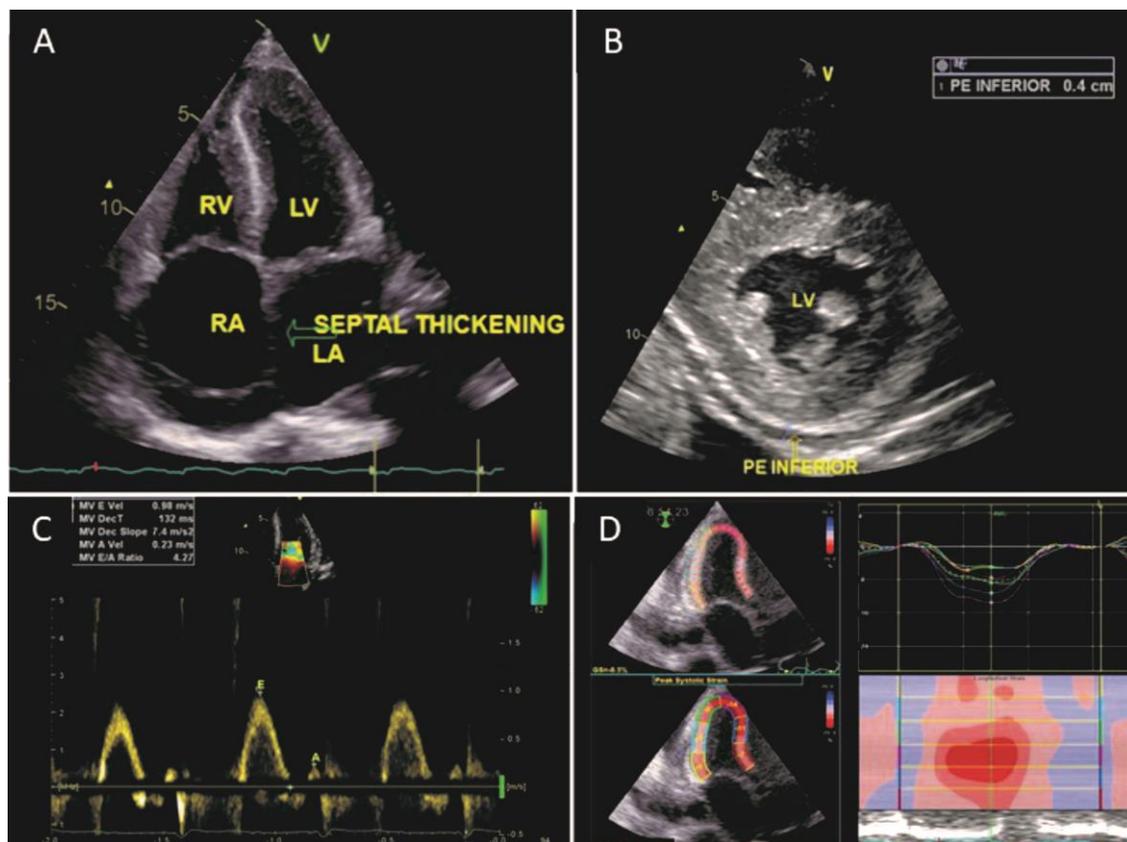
Echocardiography in the apical 4-chamber view (A) and short-axis view (B) demonstrates the granular sparkling appearance of the hypertrophic myocardium. The LV wall is thickened with a homogenous texture of the interatrial septum, mitral, and tricuspid leaflets. The RV free wall is also thickened. There is a mild inferior PE.
